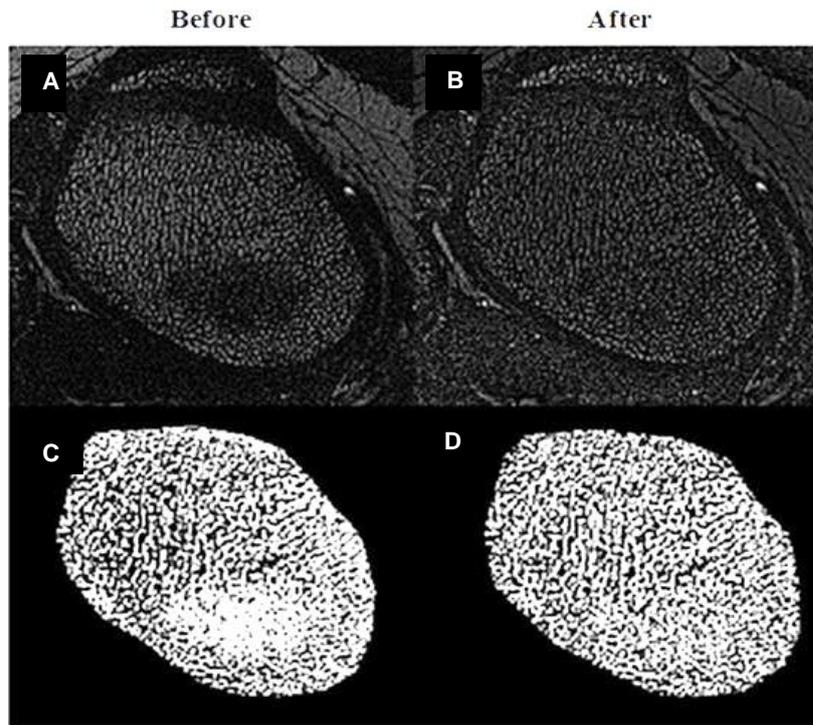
MRI axial image before (A) and after (B) application of sharpening filter.
